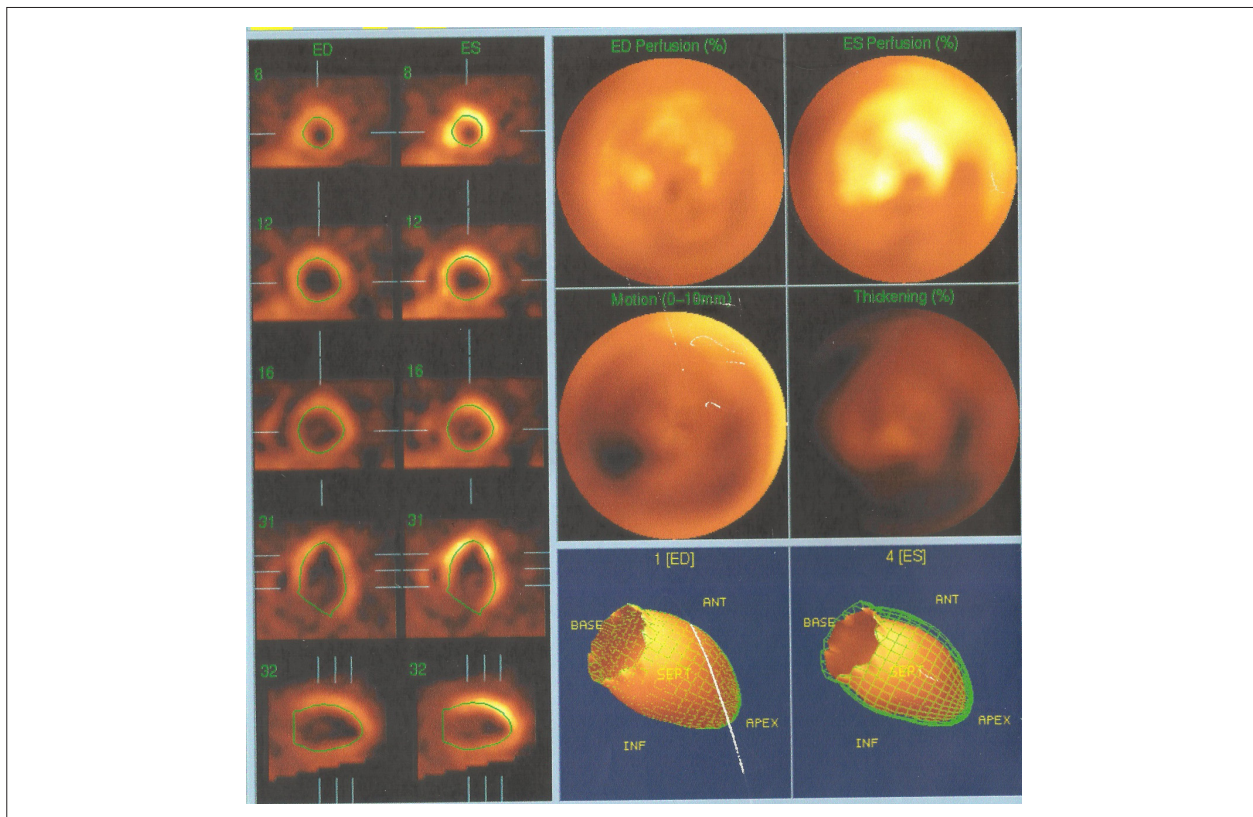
Nuclear ventriculography (gated SPECT scan): Diffuse left ventricular hypokinesia.
